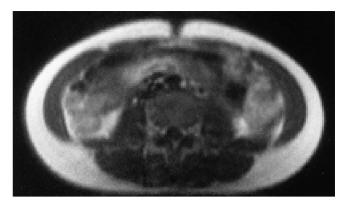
Abdominal MRI at the level of the umbilicus. Note that subcutaneous abdominal adipose tissue (SAAT) was clearly demarcated in the MR images and therefore easily measured. In contrast, intraabdominal adipose tissue (IAAT) was not as well outlined in this population of nonobese adolescent males.
